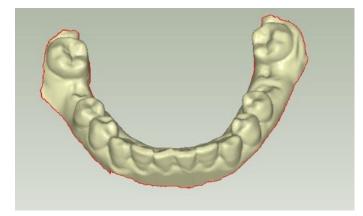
The dental model from CBCT.
